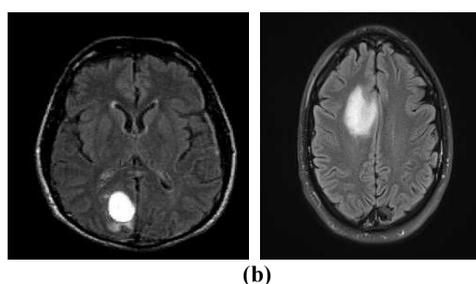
MRI Brain Images
